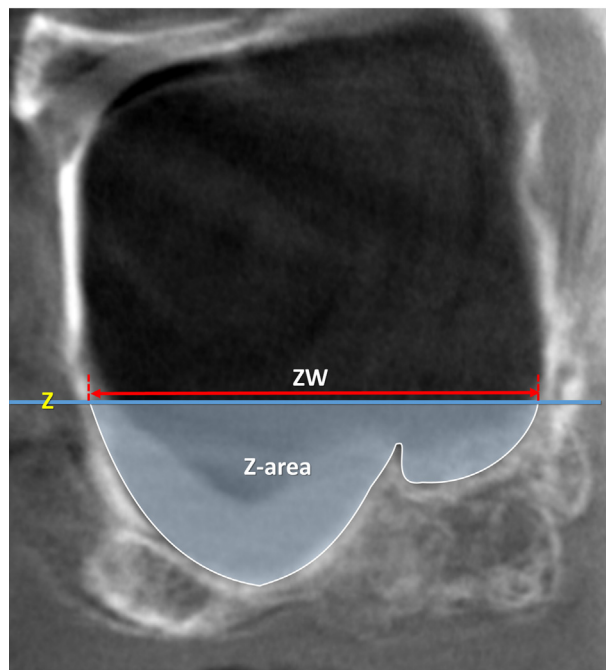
Lateral view of a CBCT before sinus floor augmentation. Z, line drawn following the floor of the nose; ZW (sinus extension), i.e. the distance evaluated on the line Z between the two intersection points with the mesial and distal sinus bone walls. Z-area, area delimited by the sinus bone walls and the line Z.
